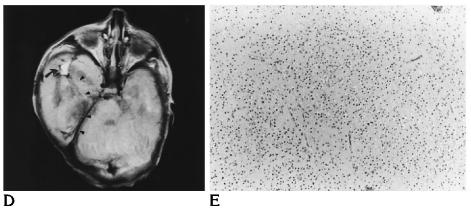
A, Coronal ultrasound of the brain shows an intracranial extracerebral mass in the right temporal region, marked by crosses (x). Separation of the mass from the cerebrum is outlined by thin arrows. The echogenicity of the mass is similar to normal cerebral tissue. An inhomogenous echogenic and cystic structure (thick arrow) can be delineated at the floor of the middle cranial fossa. Medial and cranial displacement of the temporal lobe by the mass can be seen. A clear-cut differentiation of the mass from the surrounding cerebral tissue is possible.
